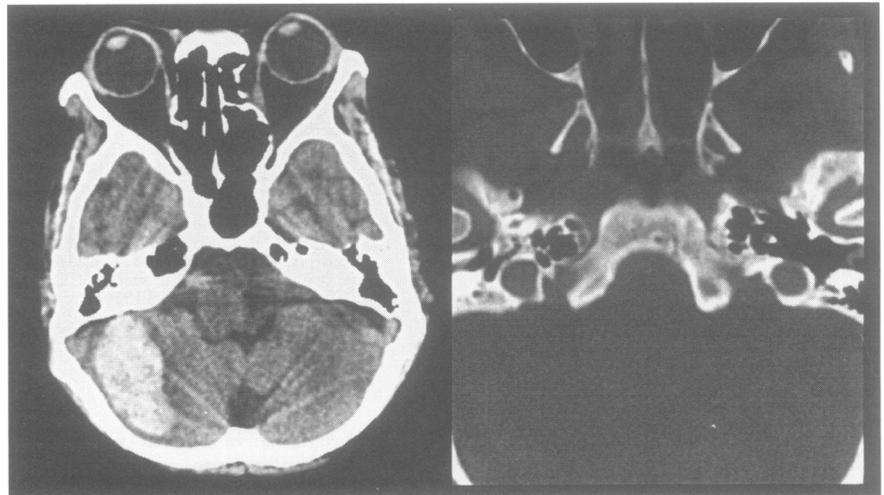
Left: CT showing a haematoma in the subcortical region of the right cerebellar hemisphere. Right: High resolution skull base CT showing complete absence of the carotid canals on both sides.
